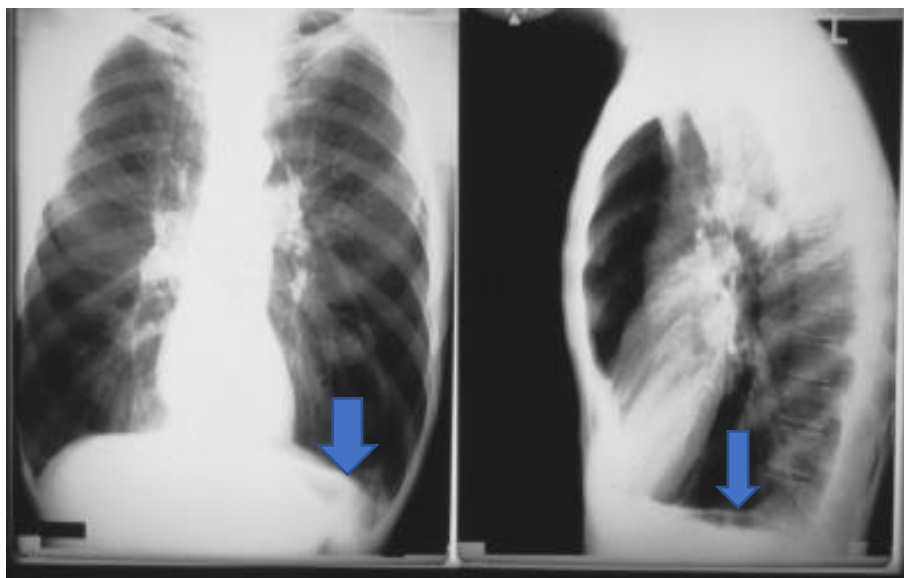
Plain radiograph taken of a patient undergoing lung volume reduction procedures at Liverpool Heart and Chest Hospital showing hyperexpanded chest with flattened diaphragm (blue arrow).
